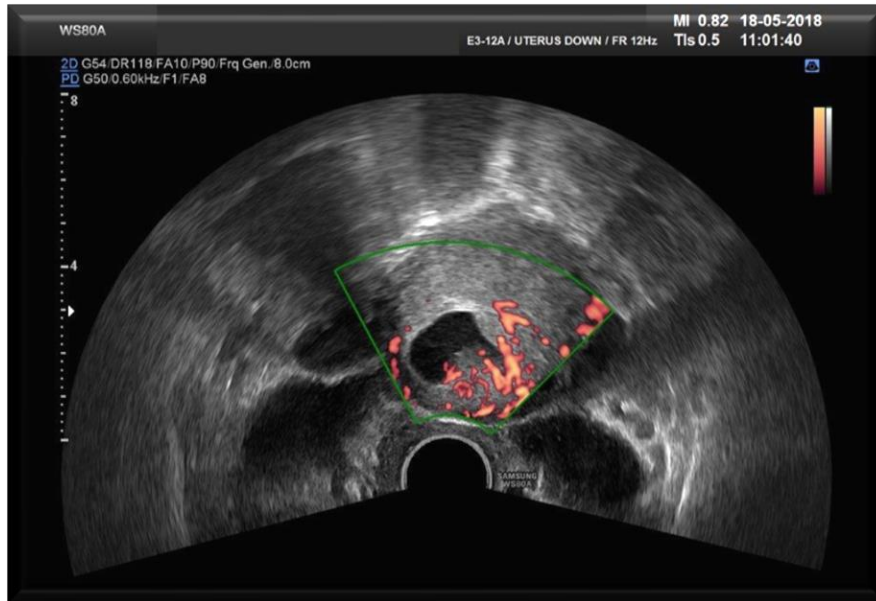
first case described on transverse scan the diagnosis of an implantation of the placenta right cranial – to the cervical canal – to fundal - towards the uterine cavity – on the longitudinal axis can be made easier by Doppler imaging (Type 1 CSP).
